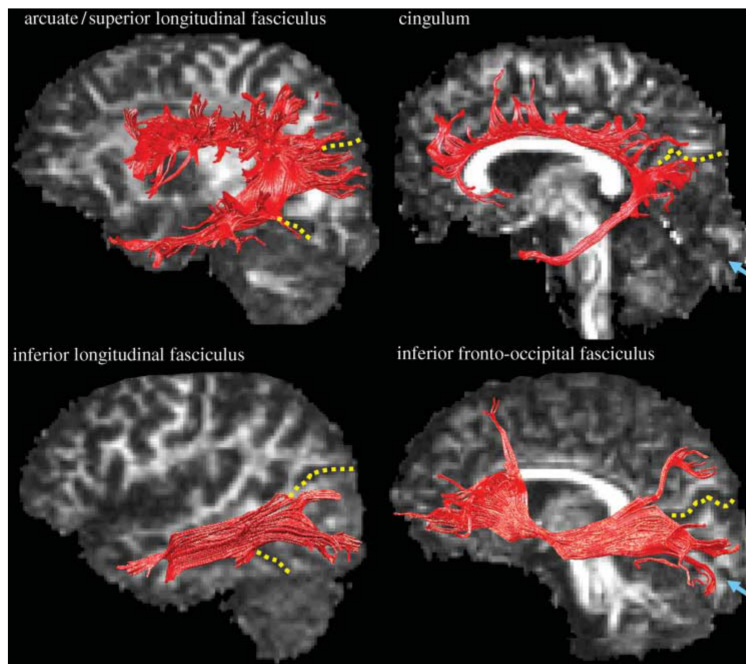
Long range cortico-cortical association tracts delineated using diffusion tractography. Tractography was performed in the left hemisphere of a single individual. Tracts are overlaid on sagittal and parasagittal MRI slices through the opposite hemisphere to the displayed tract. Image is taken from Catani et al. [65].
